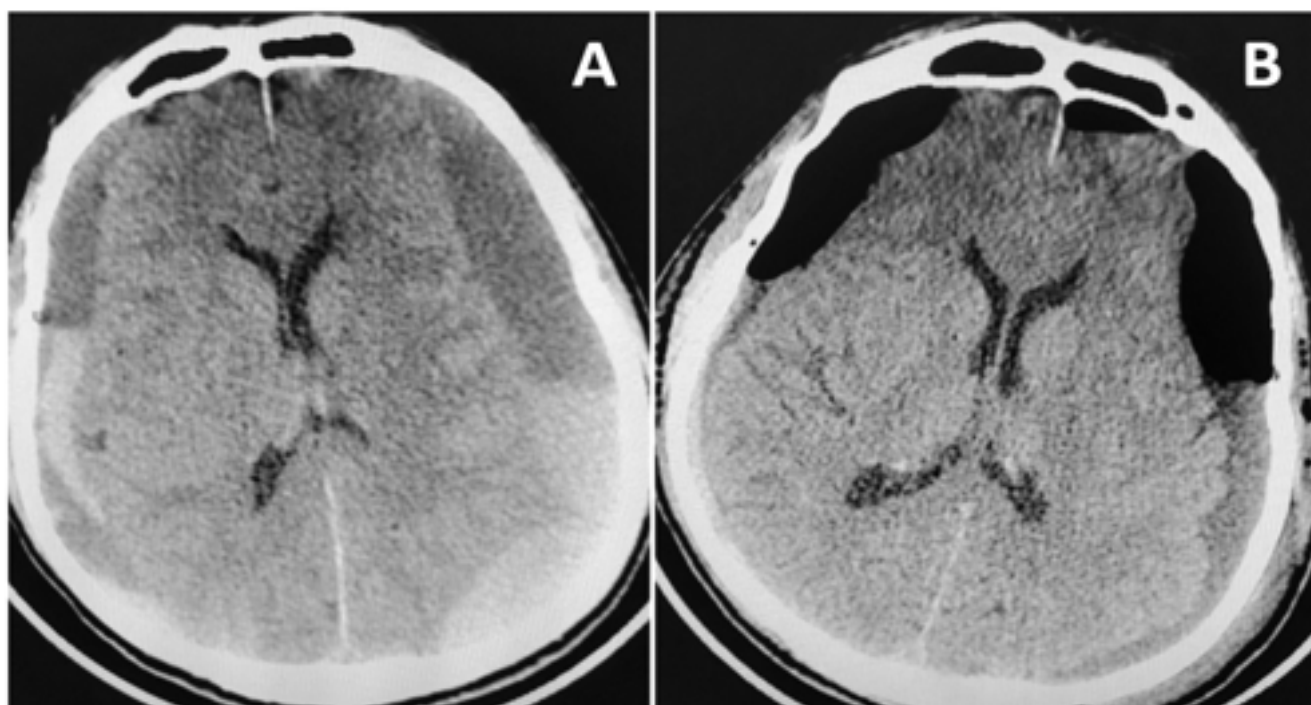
A. Preoperative CT brain scan showing bilateral chronic subdural hematoma with double density. B. Post-operative CT scan showing decompression of the brain.
